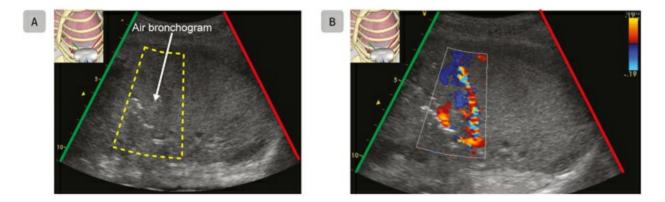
Hepatization of lung parenchyma. (A) A lung ultrasound 2D image obtained with a convex probe of the left lower lobe (zone 8) shows lung parenchyma that has the same appearance as (B) normal hepatic parenchyma.
